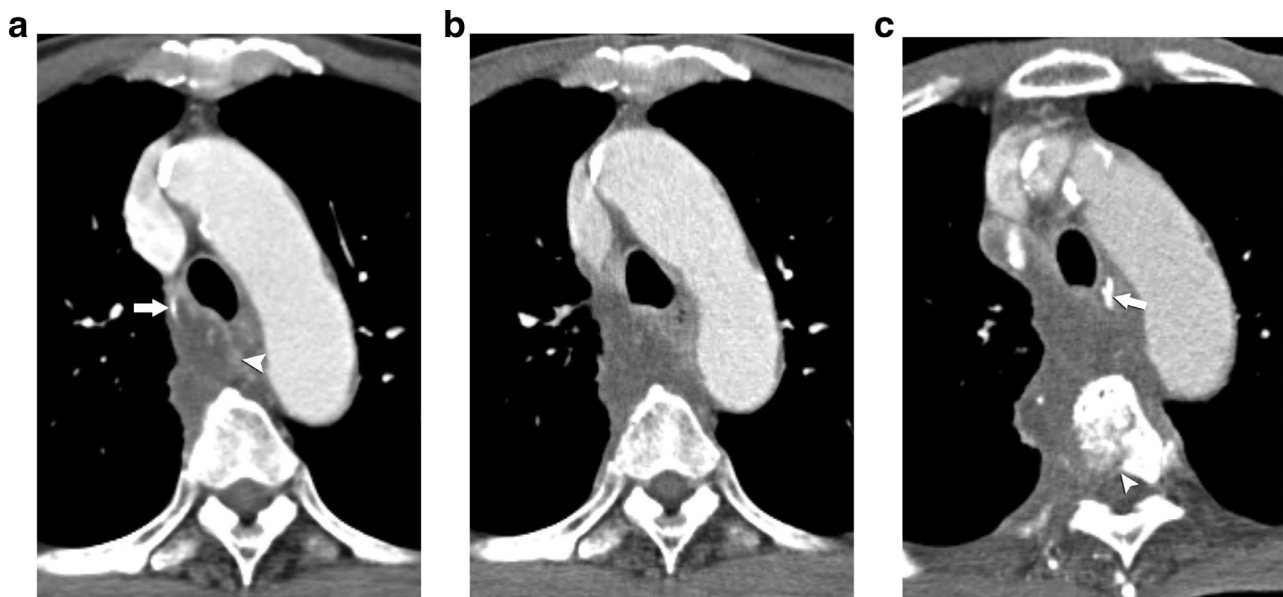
(A) Postcontrast CT scan at the level of the aortic arch shows about 38 x 25 x 57 mm sized ill-defined, infiltrative, low-attenuating mass engulfing the azygos vein (arrow) with subtle peripheral enhancement (arrowhead) in the right paratracheal area. There is loss of fat plane between the lesion and the adjacent trachea, esophagus, and vertebral body. (B) After 4 months, CT scan reveals increased extent of the mass along the pleura and mediastinum. (C) Follow-up CT scan in 3 months shows increased infiltration of the tumor with invasion into adjacent structures including the esophagus and vertebral body. The infiltration of the esophageal wall by the tumor is seen. There is subtle residual oral contrast material in the esophageal lumen (arrow). The bony destruction of the fourth thoracic vertebral body (arrowhead) is also noted.
